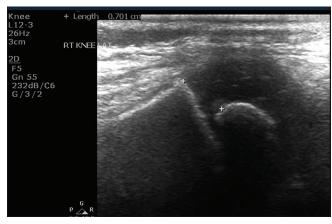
Greyscale ultrasound image of the right knee, showing femoral growth plate measurement at its maximum diameter at lateral condyle. The hypoechoic part between the + sign is the growth plate or physeal plate
